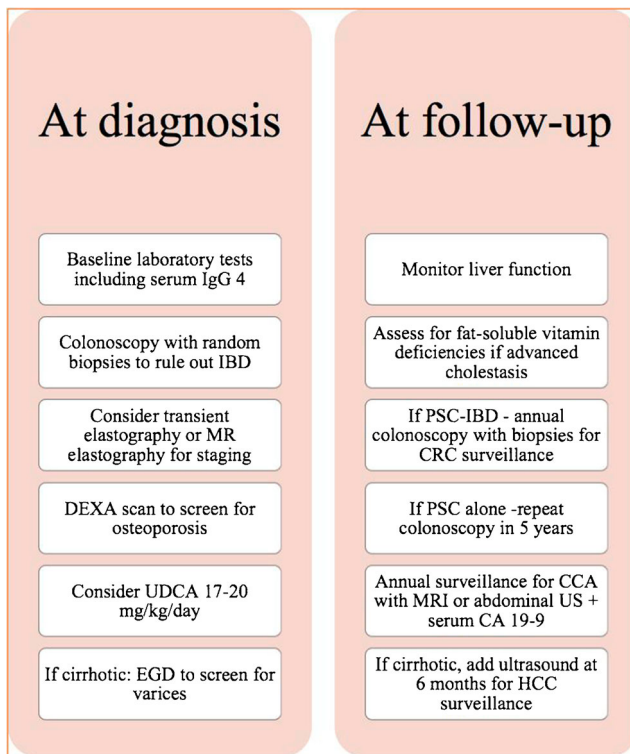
Management recommendations at diagnosis and follow-up of a patient with primary sclerosing cholangitis (PSC); IgG4 immunoglobulin G subclass 4, IBD inflammatory bowel disease, MR magnetic resonance, DEXA dual-energy X-ray absorptiometry, UDCA ursodeoxycholic acid, EGD esophago-gastric duodenoscopy, CRC colorectal cancer, CCA cholangiocarcinoma, HCC hepatocellular carcinoma. With annual surveillance for CCA, we are automatically surveying the gallbladder as well
